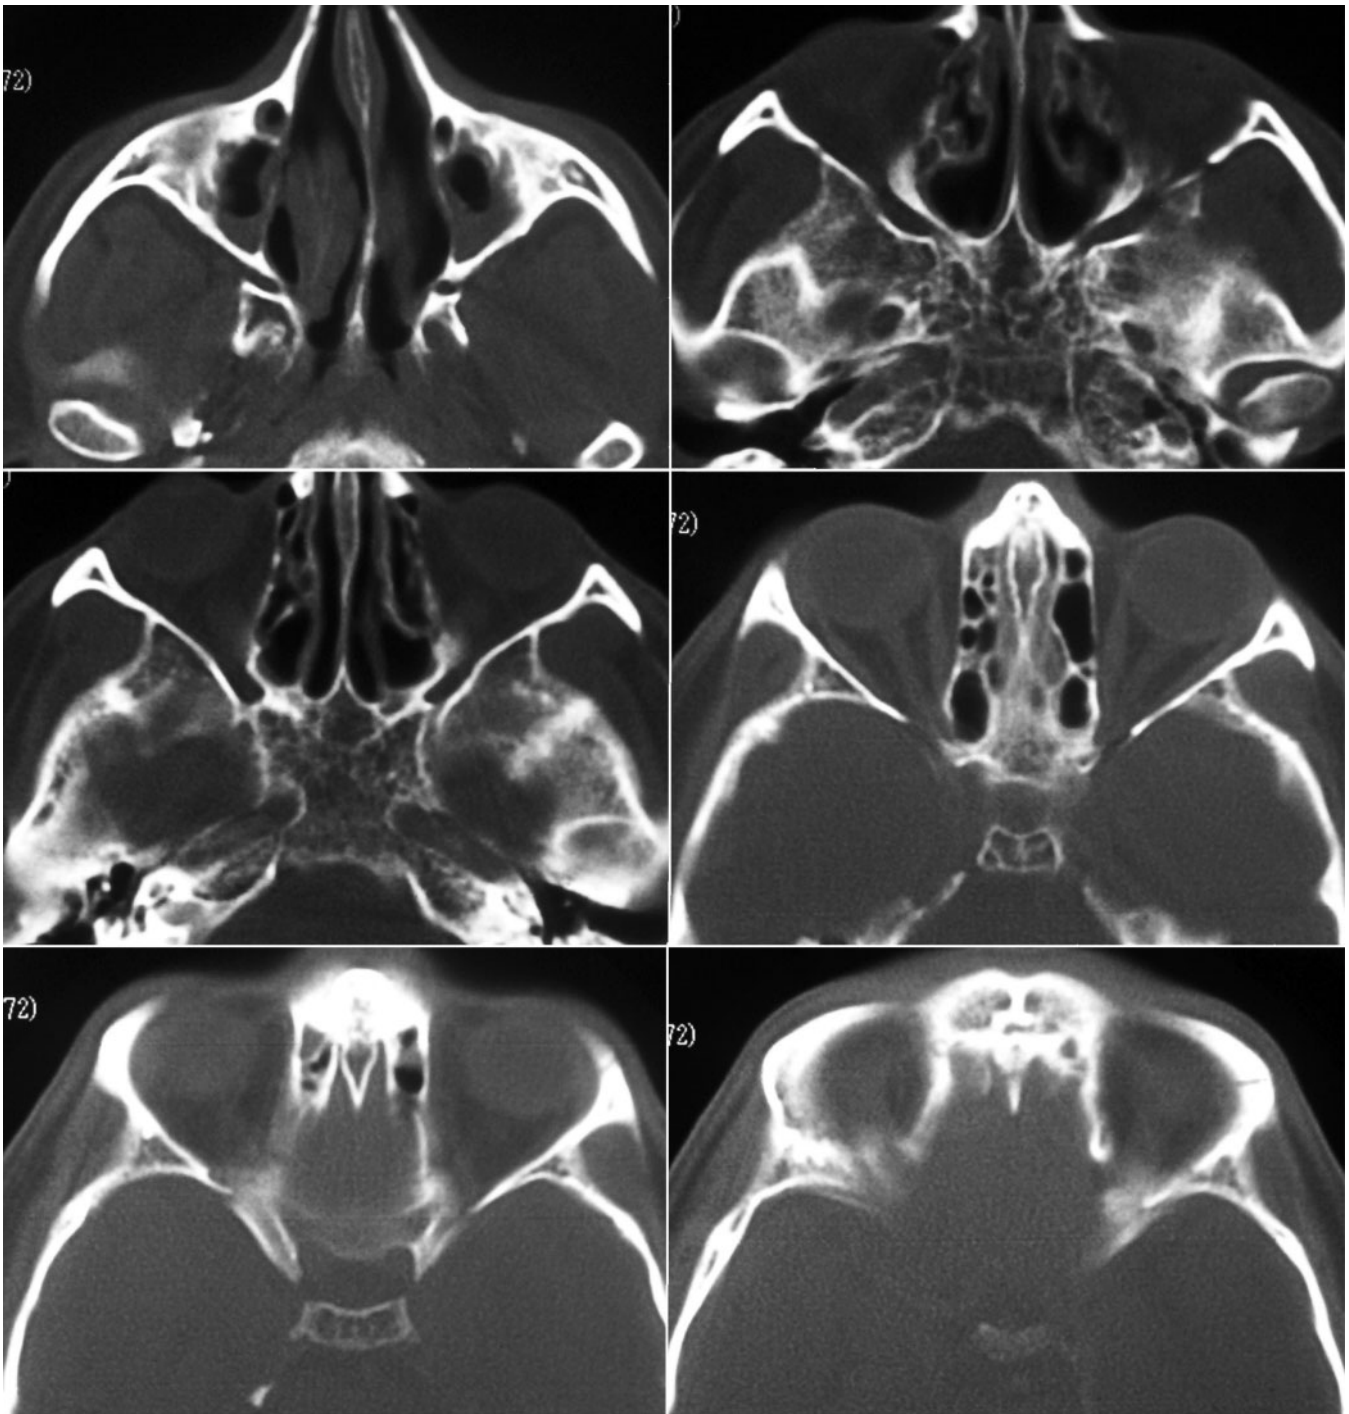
Consecutive axial CT slices of paranasal sinuses demonstrates the lack of pneumatization in expected locations of sphenoid and frontal sinuses and bilateral hypoplastic maxillary and ethmoid sinuses. A slight deviation of nasal septum towards the left side and bilateral soft tissue densities in maxillary sinuses are noticed (top left).
